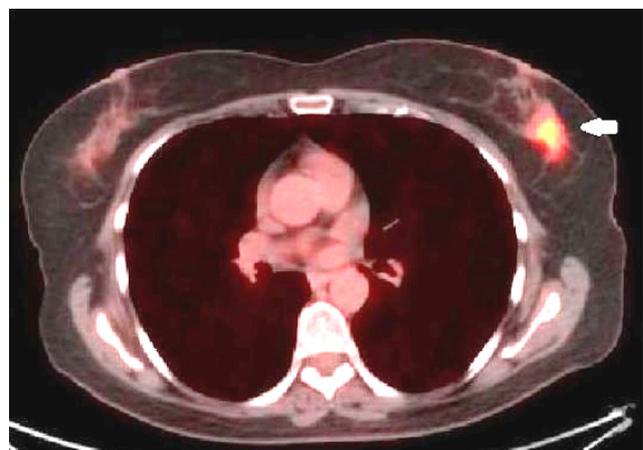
Axial ^{18}F -FDG PET/CT fusion image of the same breast cancer mass (arrow) given in Fig. 1. The SUVmax and TLG were 6.6 and 24.3, respectively.
